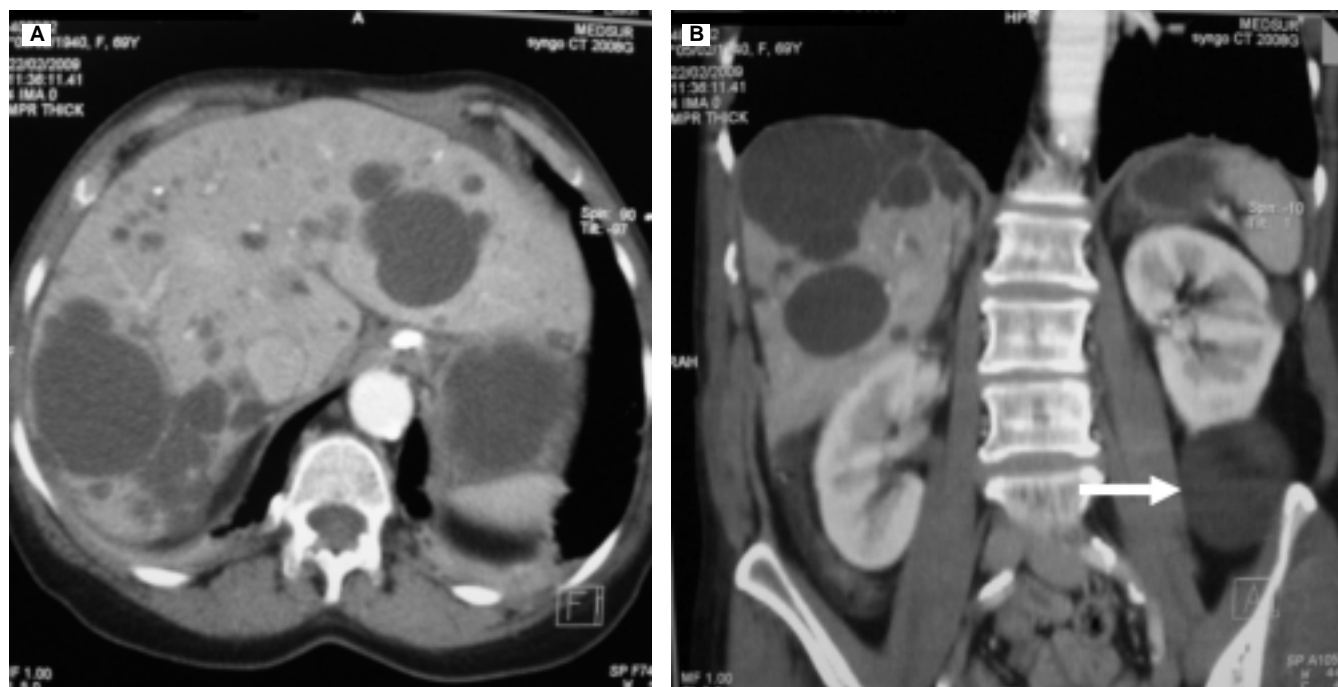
A. CT with different size liver cysts. B. Liver and left kidney cysts (arrows).
